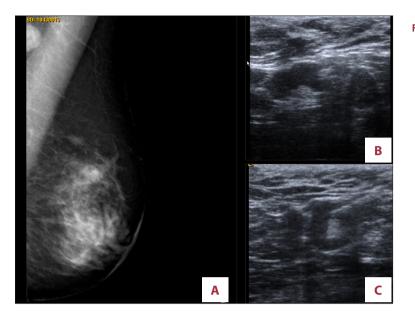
Radiologic findings. (A) Mammogram: Irregular defined mass in upper exterior quadrant of right breast, with visible axillary lymphadenopathy. (B, C) Axillary ultrasound showing hypoechoic, irregular lymph nodes.
